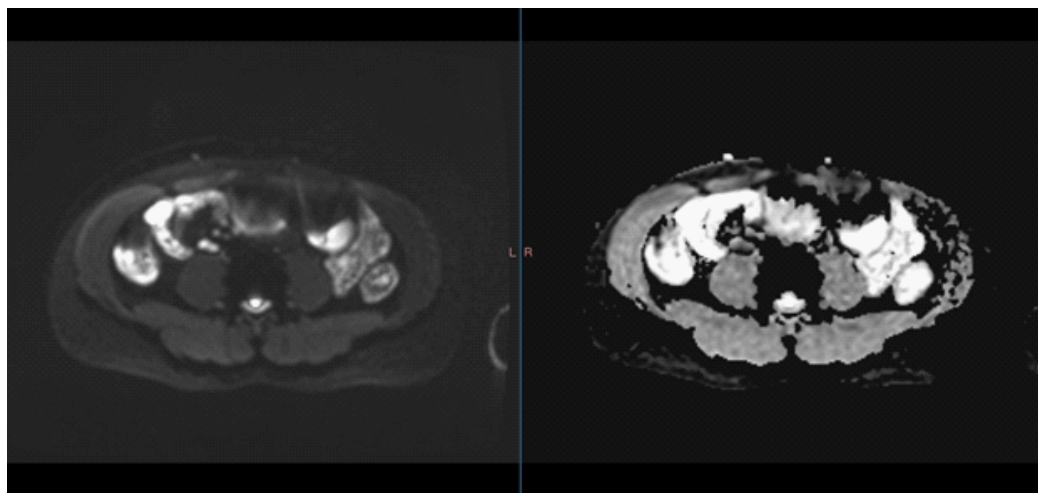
DWI and ADC map showing thickened bowel wall of the ascending and descending colon with high signal in DWI and low signal on ADC representing diffusion restriction.
